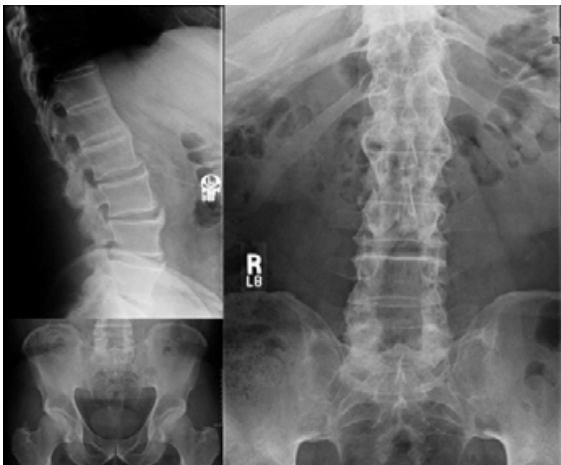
X-Rays of a UC patient with AS
